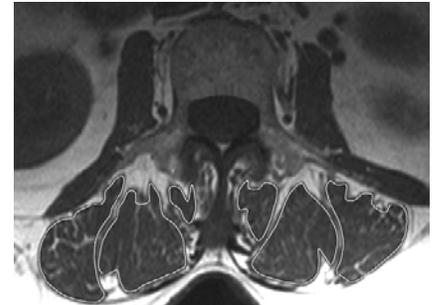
Axial T1-weighted MR image of the lumbar spine at L3 showing a manually drawn ROI encompassing the individual components of the erector spinae muscle for time intensity data-points measured from DCE-MRI.
